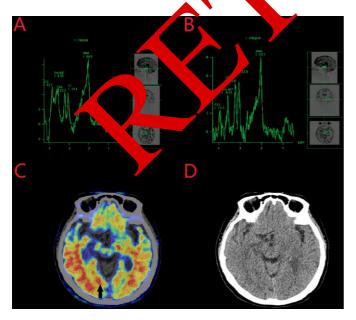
Comparison between MRS results and Amyloid-PET/CT images. MRS results (Date:
